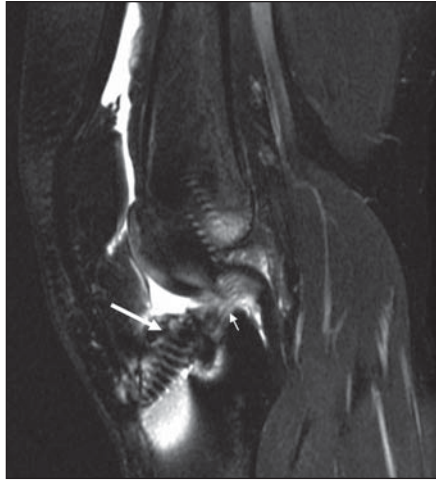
Impingement in 28-year-old man who presented for follow-up imaging 8 years after anterior cruciate ligament reconstruction. Sagittal T2-weighted fat-suppressed MR image shows part of tibial tunnel (*large arrow*) is anterior to intersection of extension of MRI equivalent of Blumensaat line and tibia (line not drawn). There is posterior bowing of graft with thinning and increased signal intensity (*small arrow*) representing edema.
